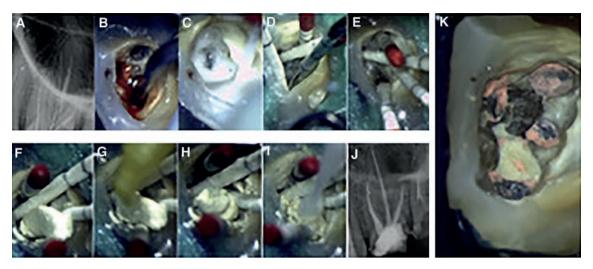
(A) K file highlights perforation in palatal root. (B) Infected dentin removing by a Start X3. (C) Disinfection and hemostasis of the perforation. (D–I) Lateral root perforation management procedure. (J) Post-operative radiograph: root canals filled after 12 min. (K) Pulp floor at the end of procedure.
